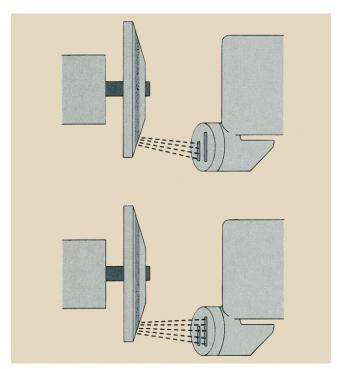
In a dual-focus x-ray tube, focal spot size is controlled by heating one of the two filaments.
